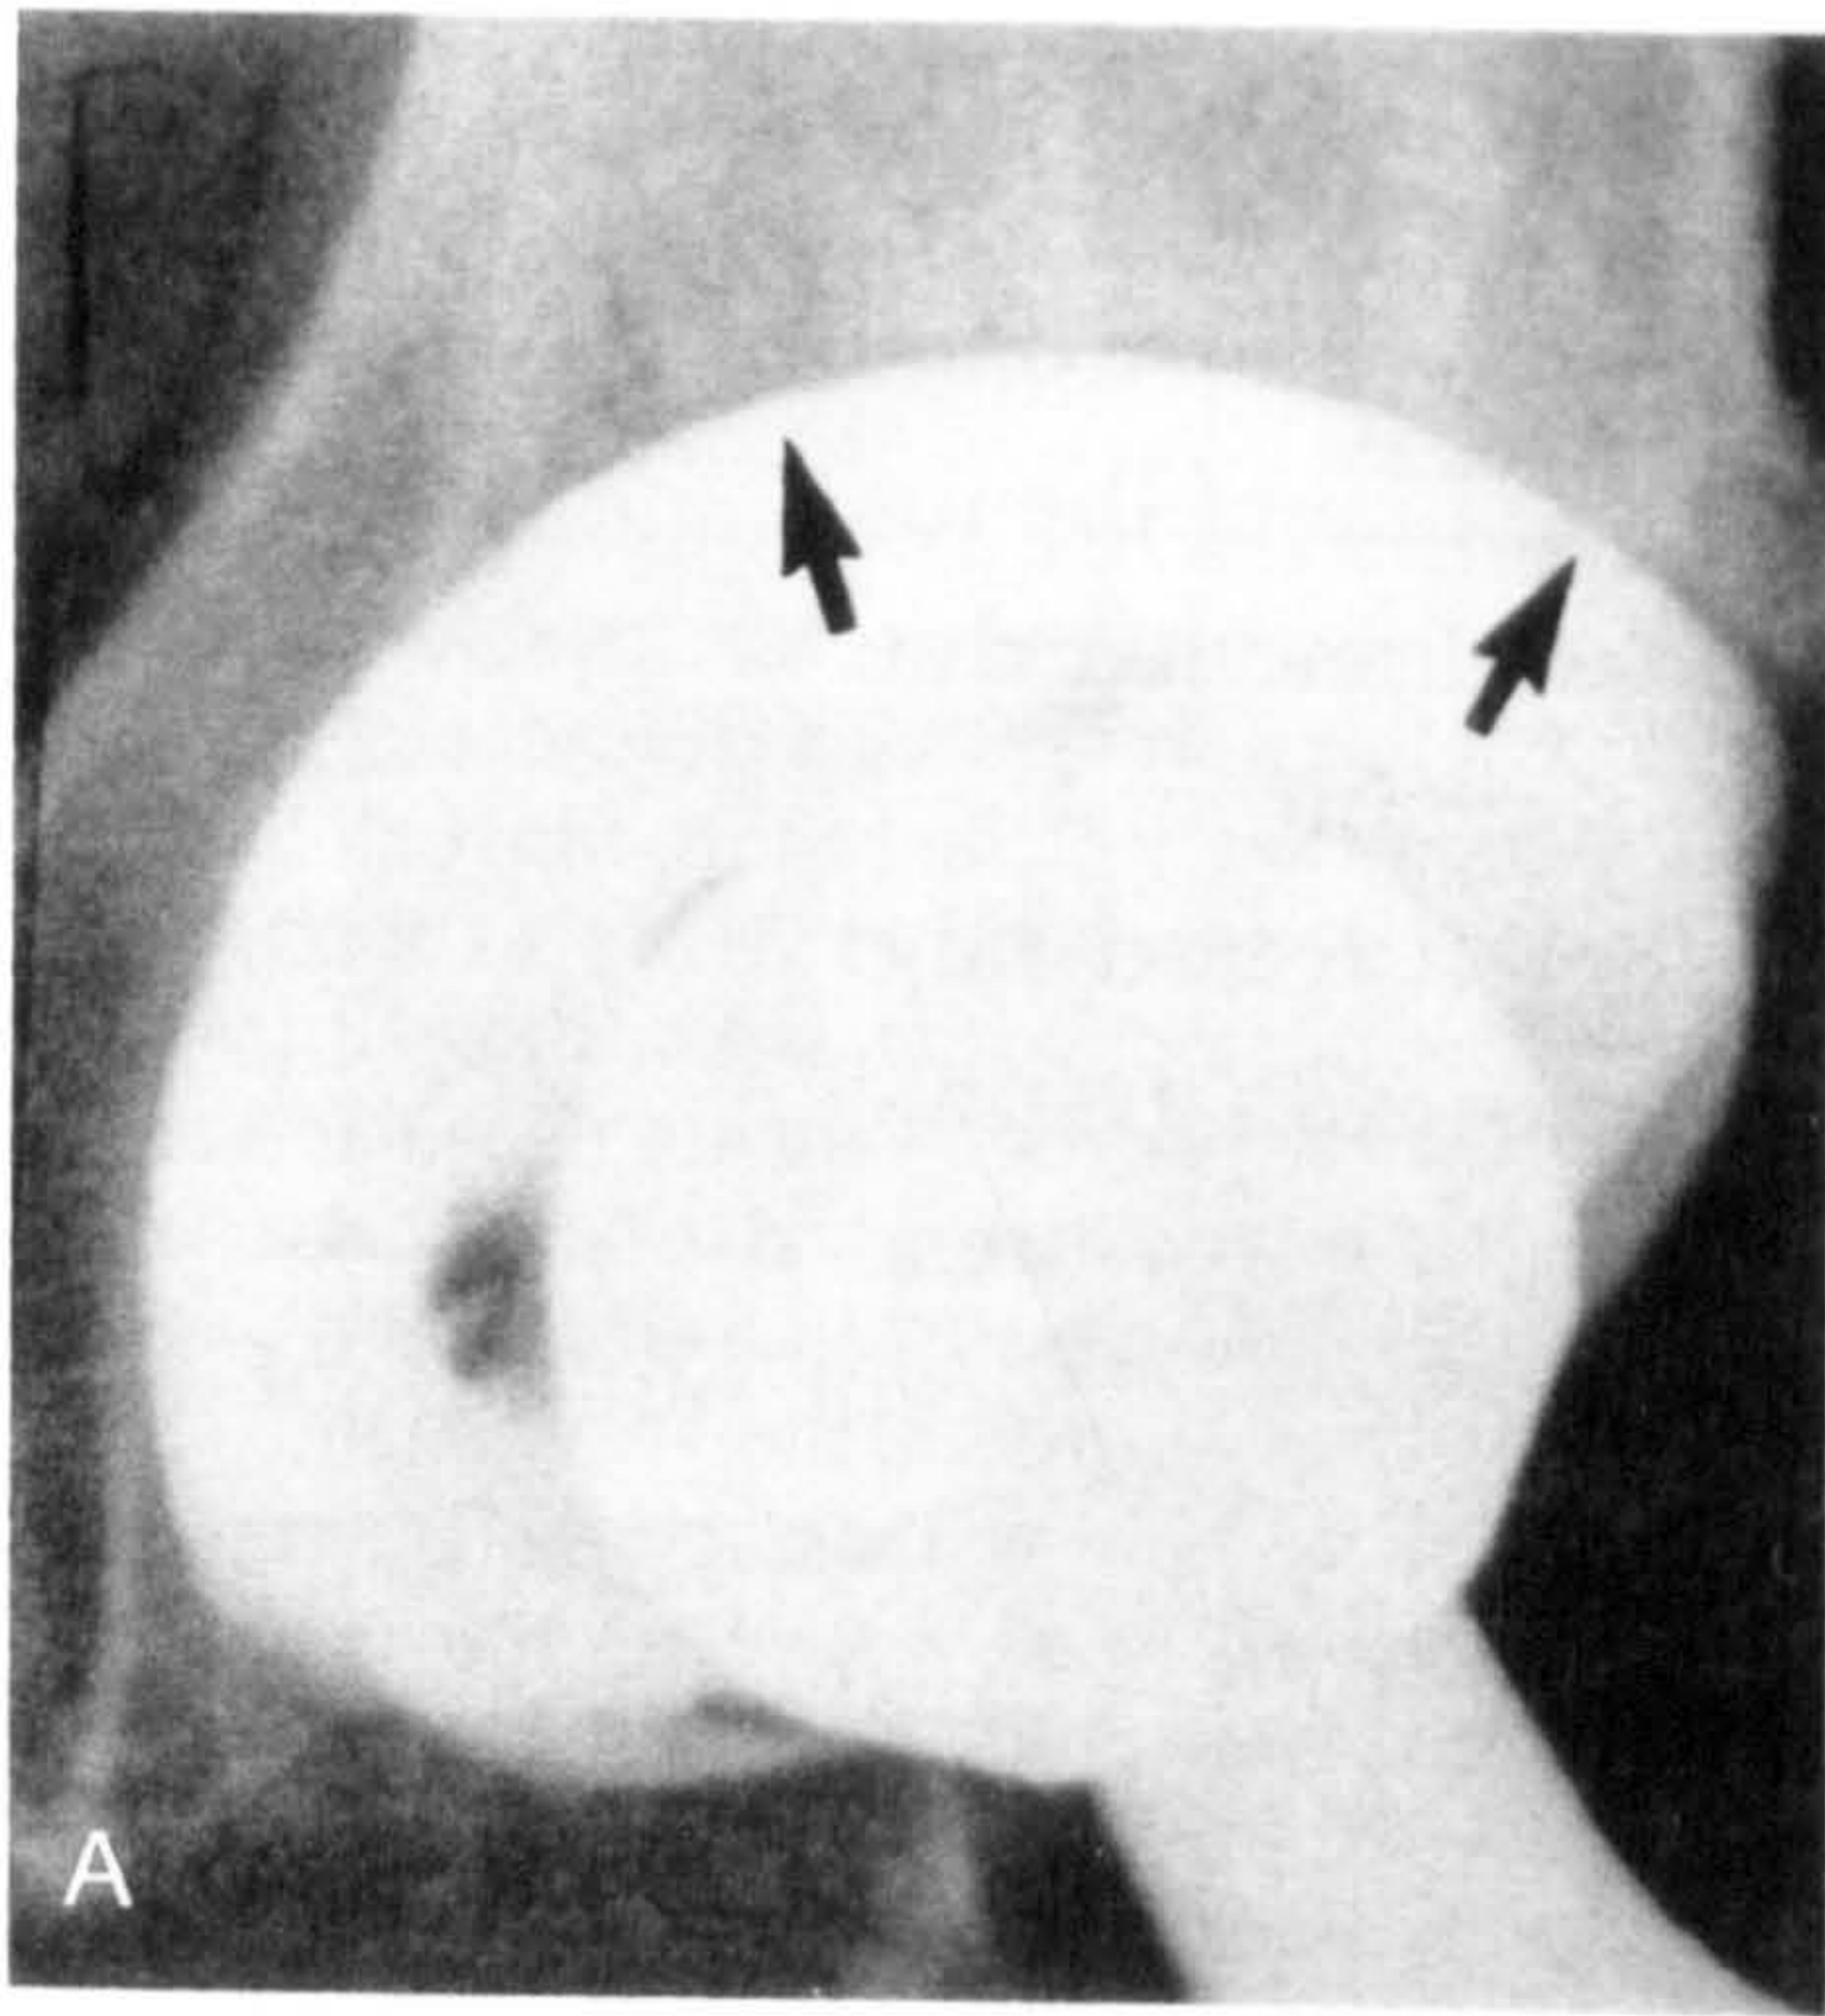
Typical radiographic appearance of a cementless acetabular cup, postoperatively (A) and at follow-up (B) as reported by Schmalzried et al (1994). Initially (A), small gaps between the porous mesh and bone are indicated by radiolucent lines (arrows). At two years post-implantation, complete resolution of the gap in zone 2 has occurred with partial resolution of the gap in zone 1. The appearance of this interface on the 5-year follow-up radiograph was unchanged.
